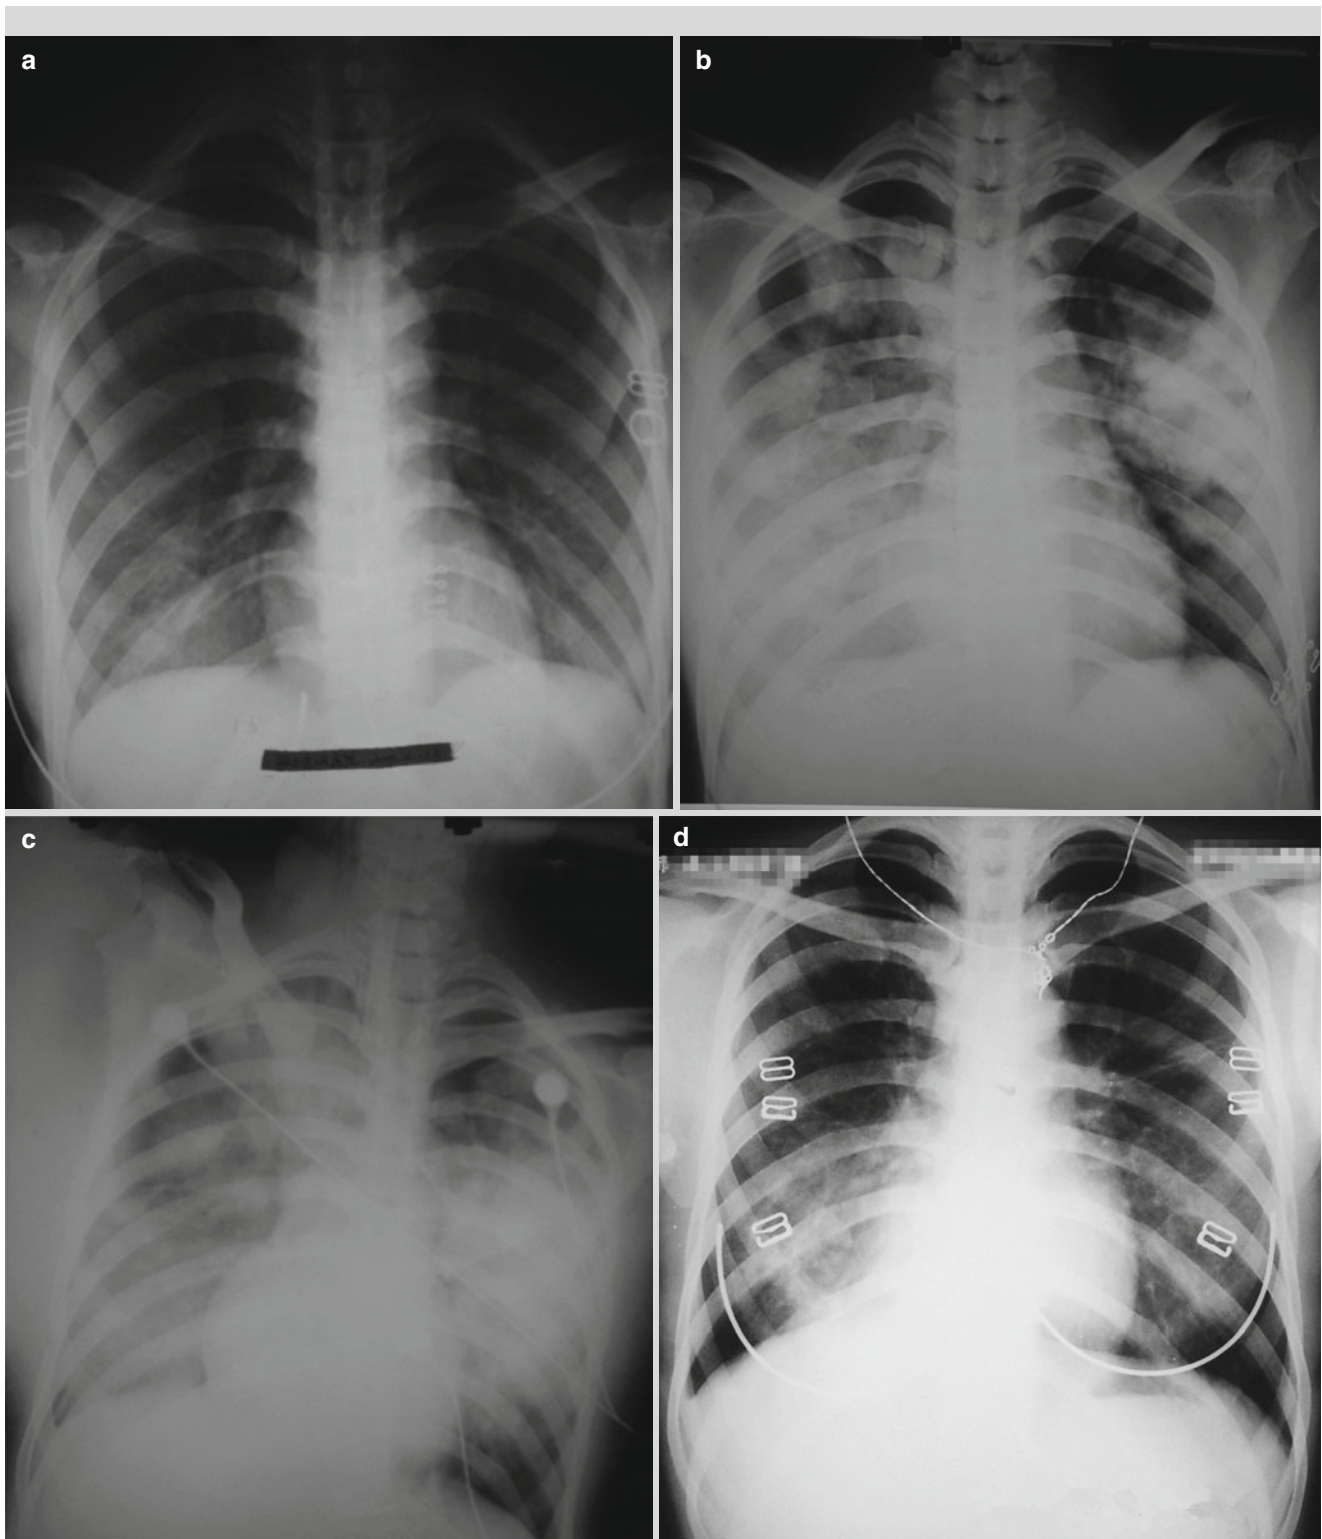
(a) On d 4 after onset, chest X-ray demonstrated poorly defined flake of light opacity in the right lower lung field, and well defined left lung. (b) On d 7 after onset, the lesions were shown with rapid progression in a larger range in both lungs. Both lungs were shown with extensive cloudy and cotton like opacity and fusion of some into large flake. (c) On d 11 after onset, the lesions were shown to be within an even larger range in both lungs, namely the white-lung sign in both lungs, which indicated relapse and progression of the lesions. (d)
